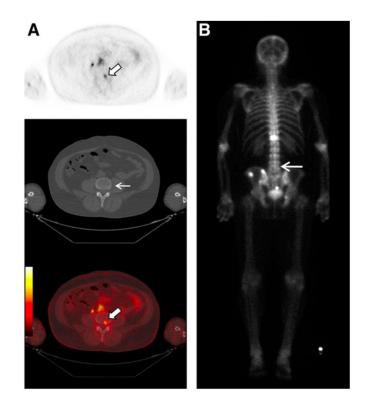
¹⁸F-DCFBC PET images in a patient with progressive metastatic prostate cancer. An area of focal ¹⁸F-DCFBC uptake in the L4 vertebral body on PET and fused PET/CT (thick arrows, A) showed no correlative abnormality on CT (thin arrow, A) or bone scan (arrow, B). Reproduced with permission from Cho et al [75].
